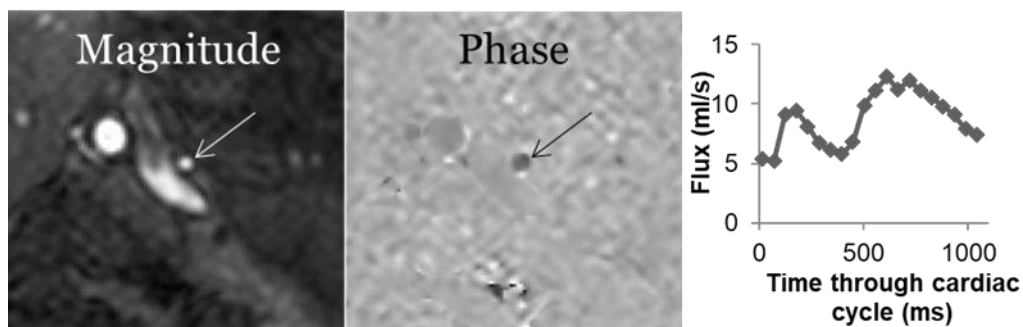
Example of phase contrast MRI, the method used to measure flux, surface area and velocity of blood in the Superior Mesenteric, Splenic and Aortic Artery and azygous vein through the cardiac cycle.
